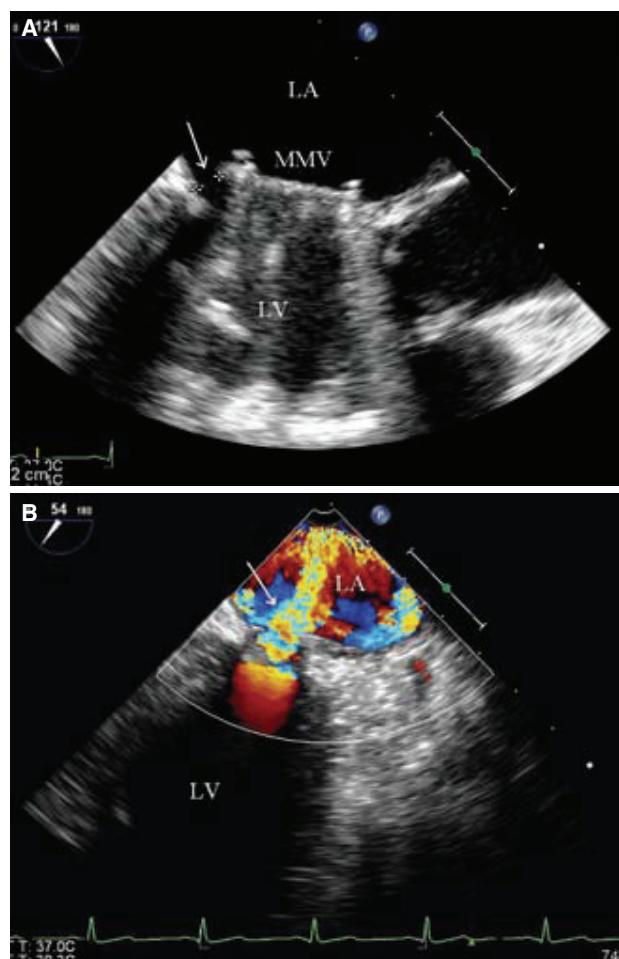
(A) Two-dimensional transesophageal echocardiographic image showing paravalvular leakage due to mechanical mitral valve dehiscence (arrow) and its width. (B) The severity of mitral regurgitation (arrow) circling along the left atrium. MMV: Mechanical mitral valve; LV: Left ventricle; LA: Left atrium.
